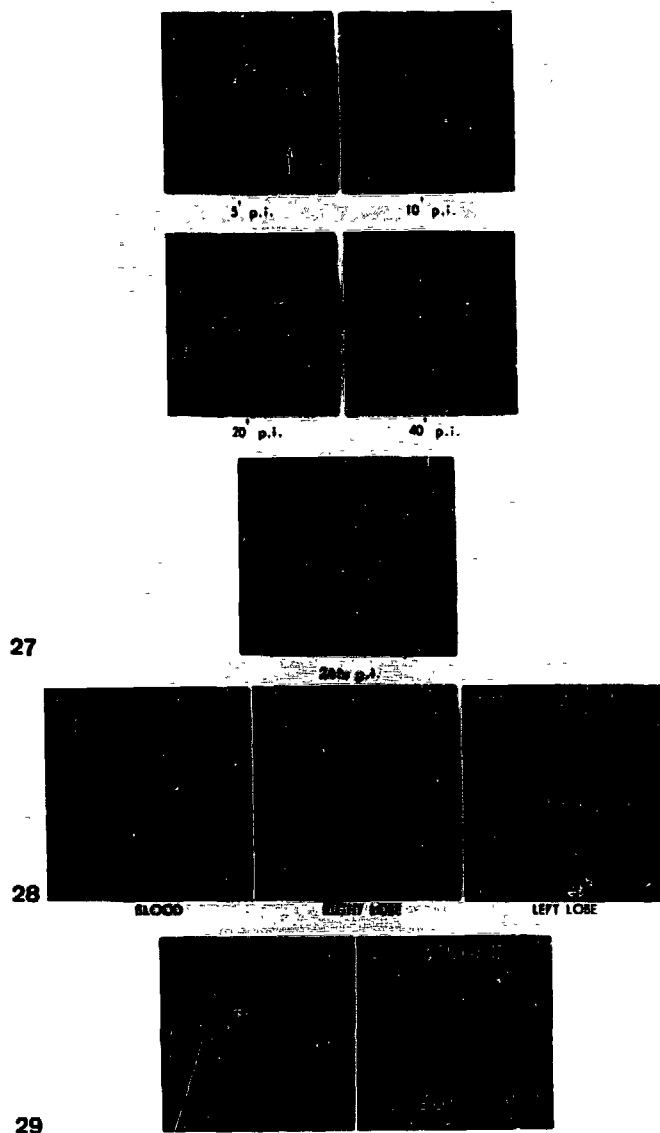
27-29 Cholescintigraphy in a patient with abnormal serum proteins due to multiple myeloma.
